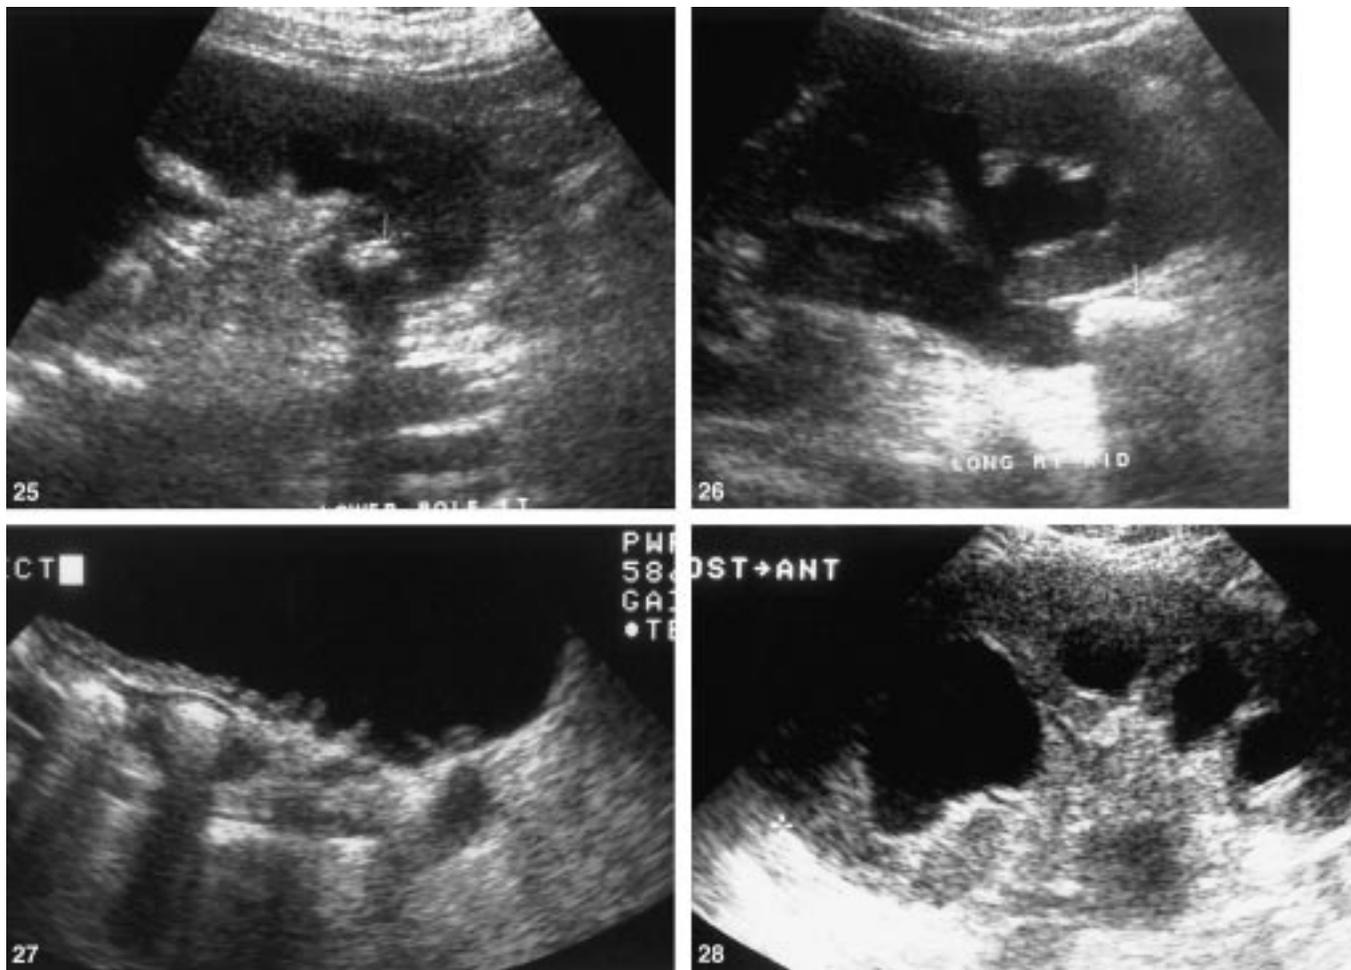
Pyonephrosis. Sagittal sonogram of the right kidney demonstrating moderate hydronephrosis with associated contained echogenic debris consistent with pyonephrosis.
